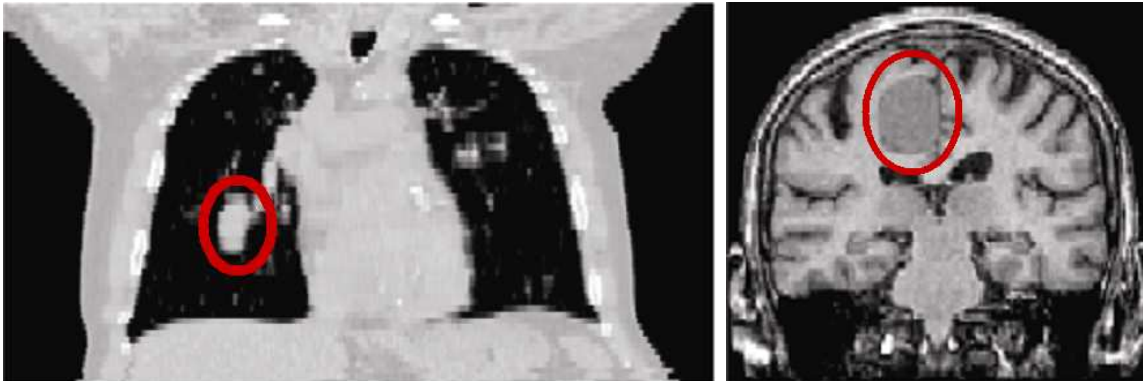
Left: tumoral thoracic image obtained with CT acquisition. Right: pathological brain image obtained with T1-MRI acquisition. A circle defines corresponding tumoral regions.
